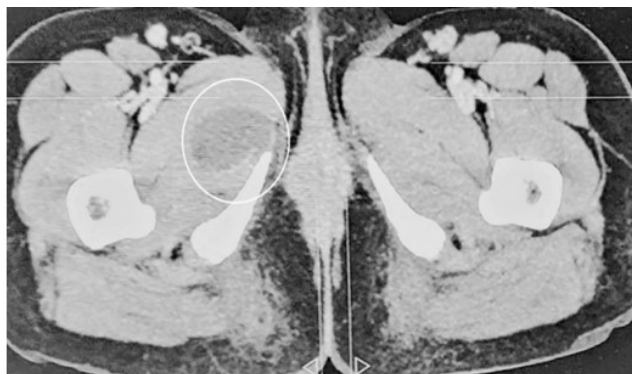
CT showing a cystic lesion in right thigh (circled)
